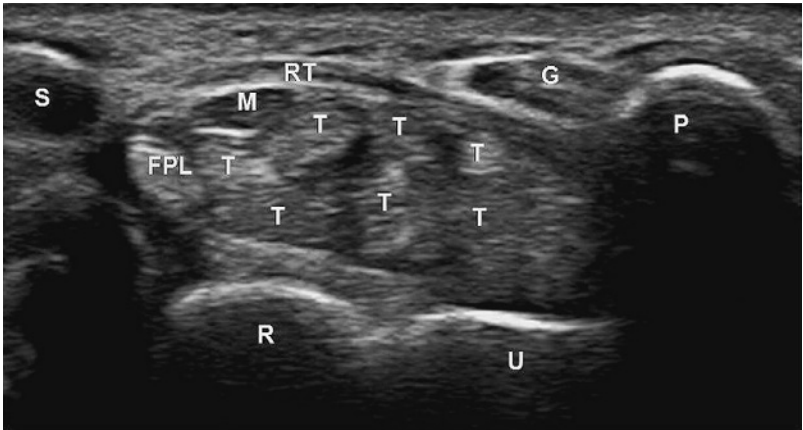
MEDIAN NERVE. Ultrasound shows the median nerve. S, scaphoid; P, pisiform; T, flexor digitorum tendon; FPL, flexor pollicis longus; M, median nerve; G, Guyon's tunnel; R, radius; U, ulna; RT, flexor retinaculum.
